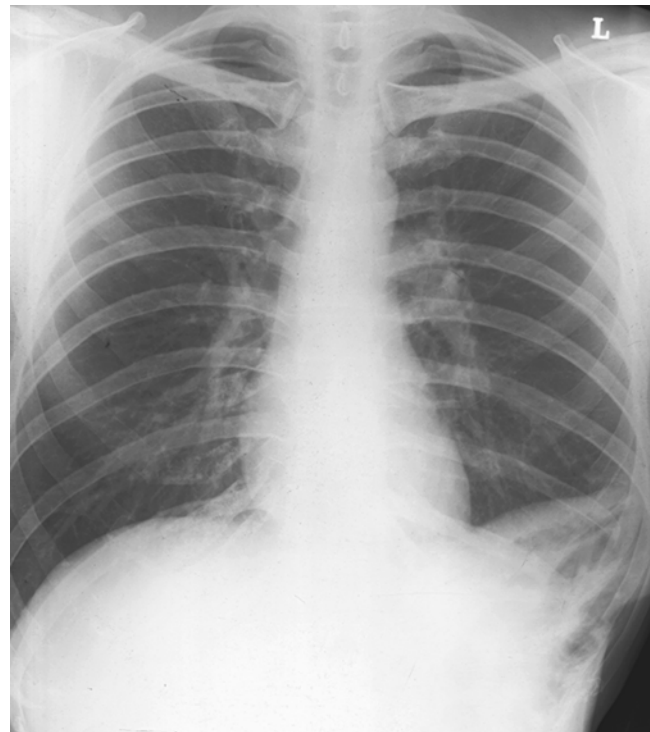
Chest x-ray 2 years after operation shows the position of the transposed left hemidiaphragm.
